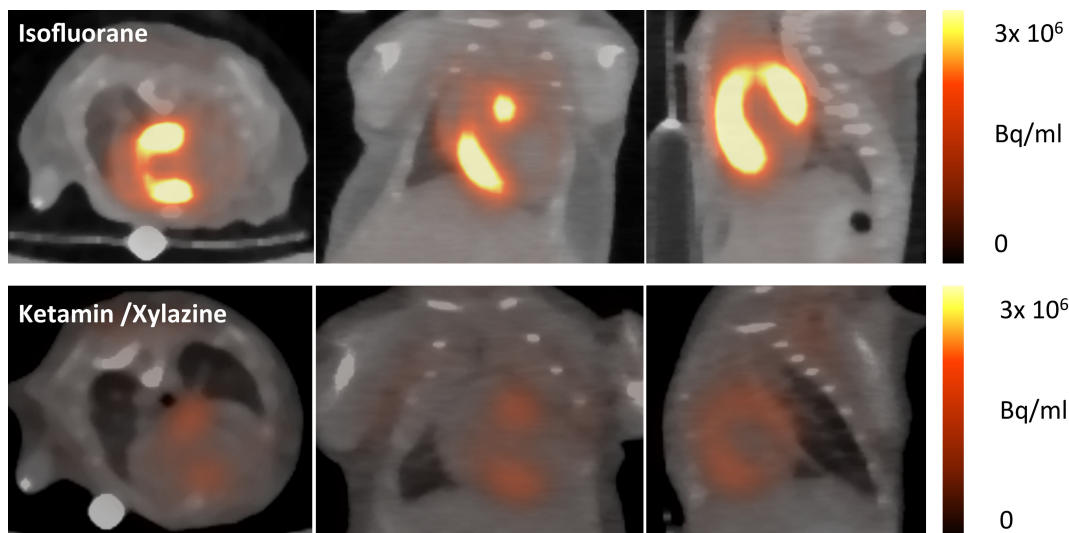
Sample axial, coronal, and sagittal myocardial ^{18}F -FDG images at five days post-surgical myocardial infarction (MI) induction. Isoflurane leads to high tracer accumulation in the healthy myocardium, whereas the infarcted area can be clearly identified as an area of low glucose metabolism (upper row). When using ketamine/xylazine, the most intense tracer accumulation is detected in the area of the border zone, whereas ^{18}F -FDG uptake in healthy myocardium remains suppressed.
